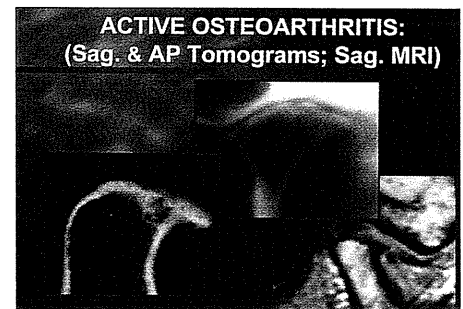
From left to right, sagittal and anterior-posterior tomograms and sagittal magnetic resonance image of active osteoarthritis in the TMJ resulting in possible sudden changes (supracontact) in the posterior occlusion on the same side.
